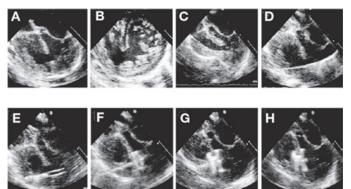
VSD device closure under transesophageal guidance
